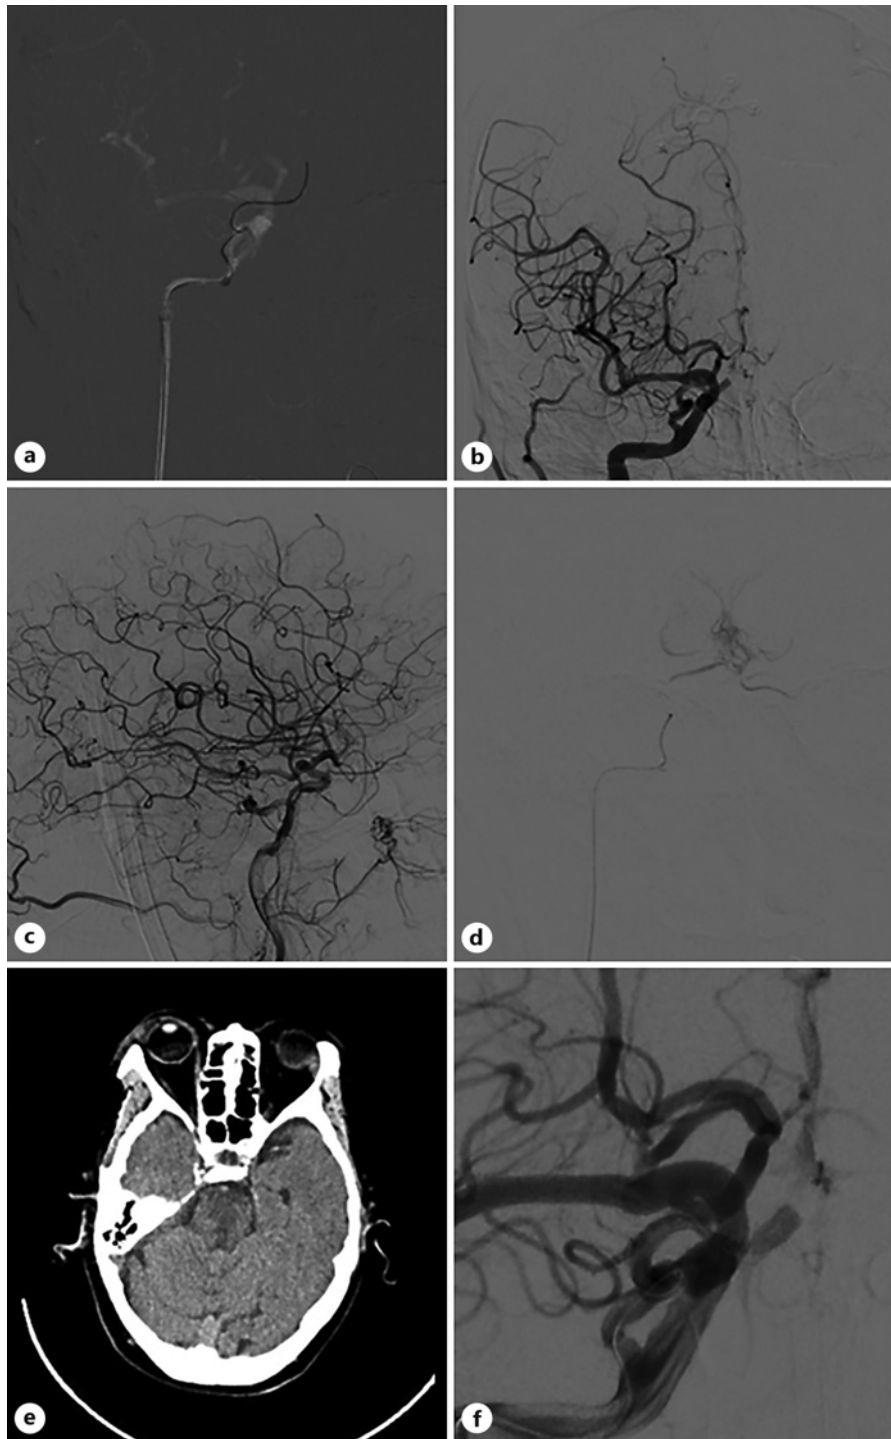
Intraoperative and postoperative images. a Avigo microguidewire successfully traversing the thrombotic occlusion segment. b, c Postoperative right ICA angiography in positive and lateral views, respectively. d Intraoperative contrast extravasation. e Head CT examination 24 h after operative, showing brain stem infarction. f Diameters of the primitive trigeminal and basilar arteries.
